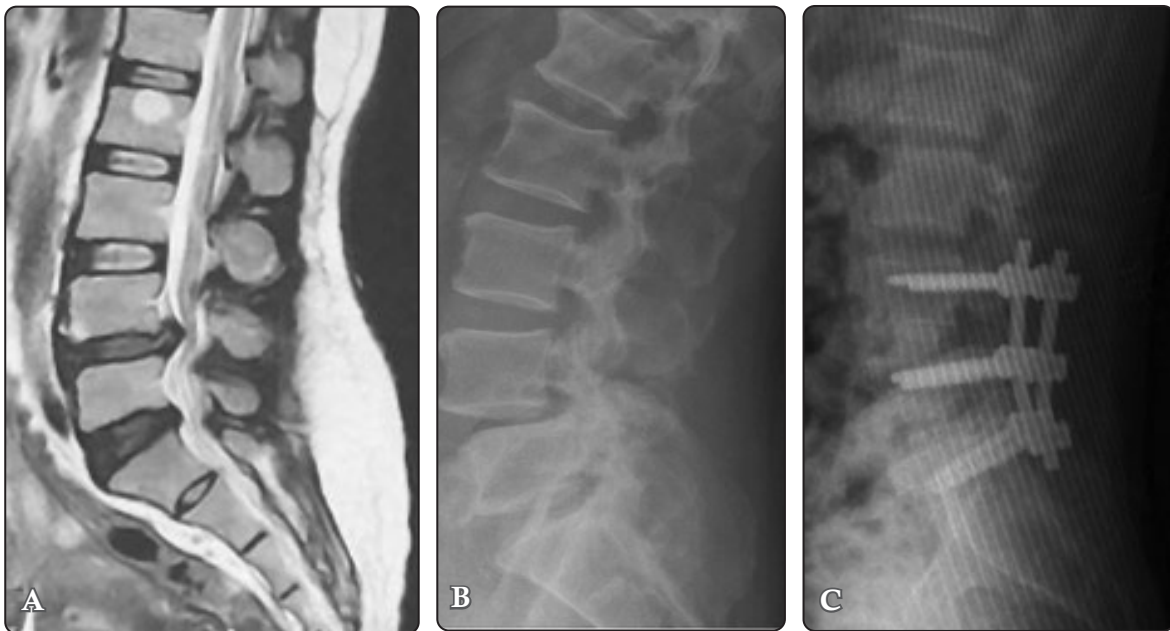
(A) T2WI sagittal MRI of a 50-year-old female with L4/L5 grade I degenerative spondylolisthesis and degenerative disc changes in L5-S1 disc. ODI= 52; VAS= 7; smoking: no; vitamin D status: normal. (B) Lateral radiograph showing the L4/L5 slip. (C) Six-month postoperative plain radiograph showing the bone graft well integrated and completely traversing the disc space with no lucencies (Bridwell's grade 1). ODI= 20; VAS= 2.
